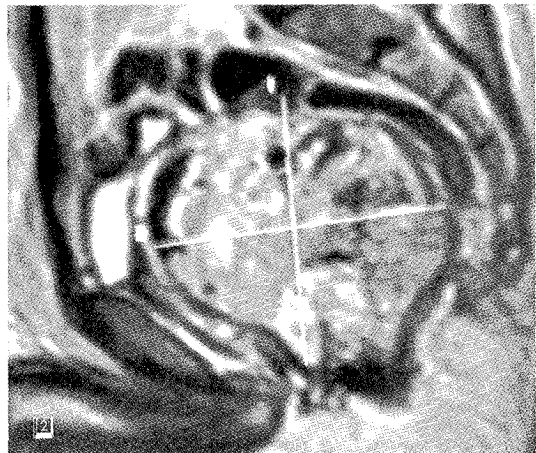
Sagittal section of T1 weighted MRI scan showing a heterogeneously enhancing mass within the prostate
